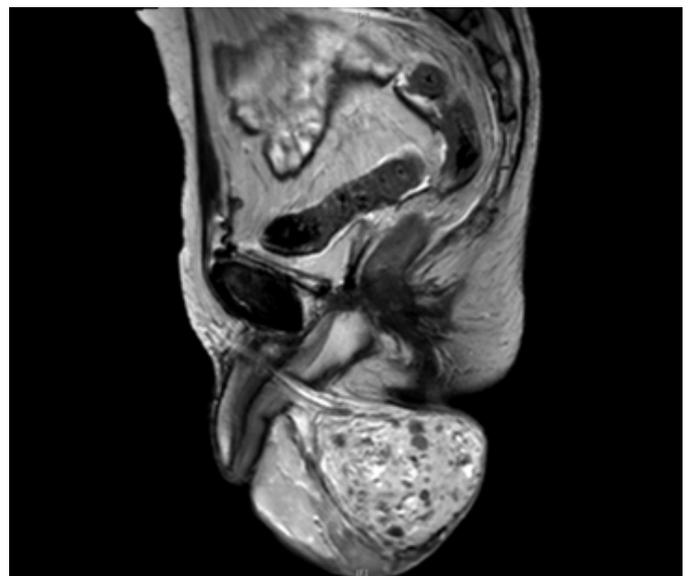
T2 magnetic resonance imaging scan sagittal view showing right testicle with multiple enhancing lesions.
